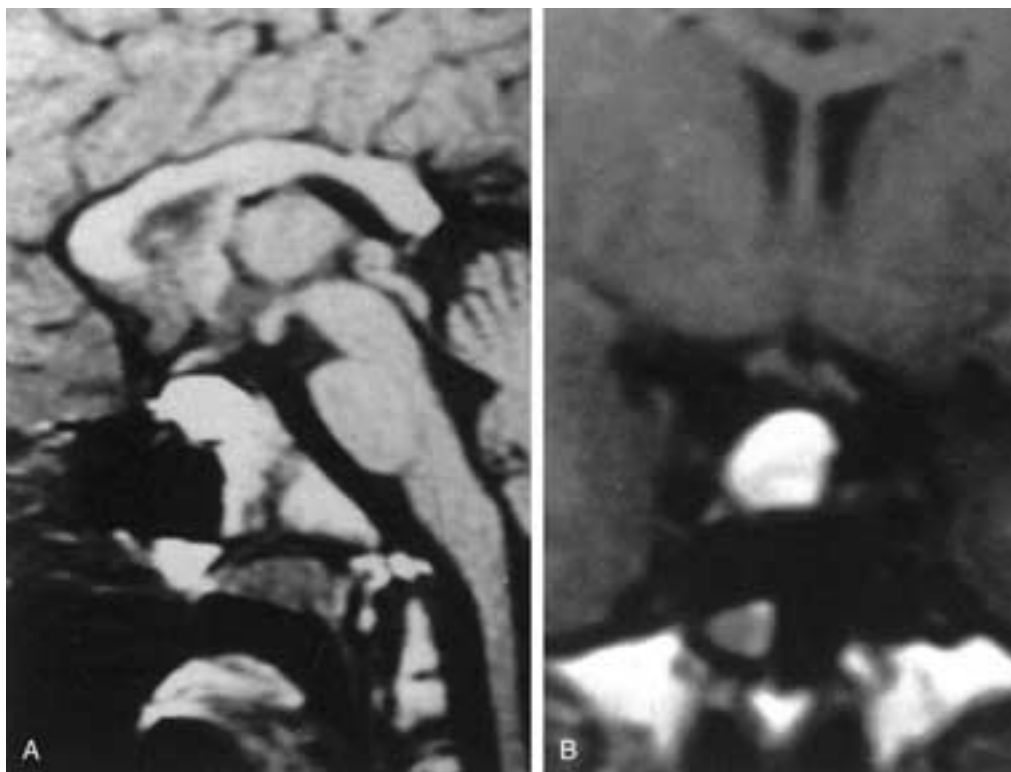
Cyst of Rathke's pouch. A, Sagittal T1-weighted image shows a hyperintense intrasellar mass bowing upward into the chiasmatic cistern just below the optic chiasm. B, Coronal T1-weighted image shows an intrasellar mass with suprasellar extension; note that chiasm is not compressed.
